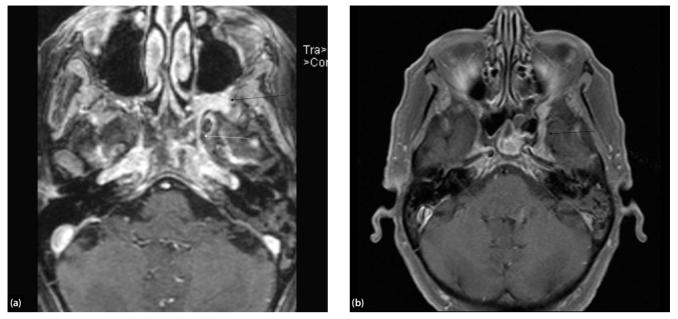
Axial VIBE (Volumetric interpolated brain examination) MRI showing left nasopharyngeal cancer (NCC) extending into the pterygopalatine fossa (black arrow) and vidian canal (white arrow) (a) and into the foramen rotundum (black arrow) (b).
